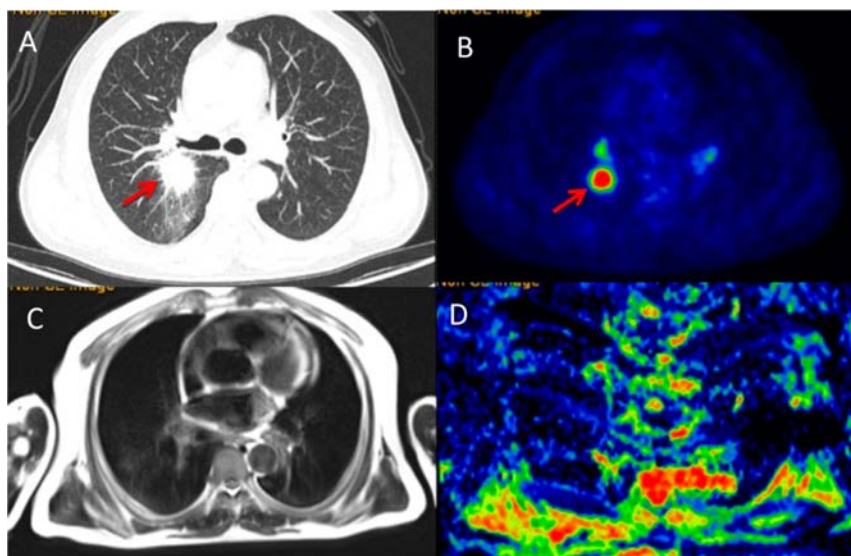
Images from a 62-year-old female with a non-small cell carcinoma lesion confirmed by pathology in the upper lobe of the right lung. Both the chest CT (A) and PET (B) clearly show the location and metabolism of the lesion (red arrow). However, it is not clearly shown at the same level by MRI (C) and DW-MRI (D) because of large artifacts.
